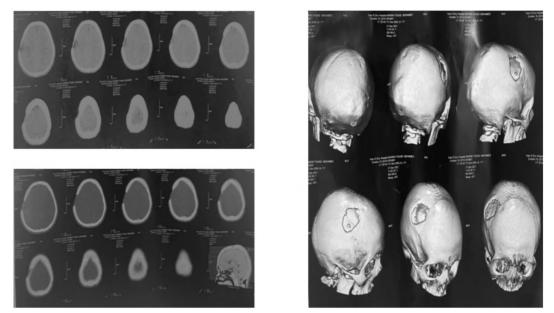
Showing CT brain with soft & bone windows as well as 3d reconstruction showing skull bone defect (case 1).
